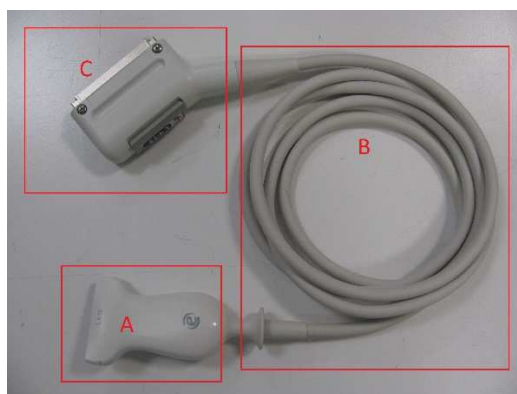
Essential parts of the ultrasound probe
